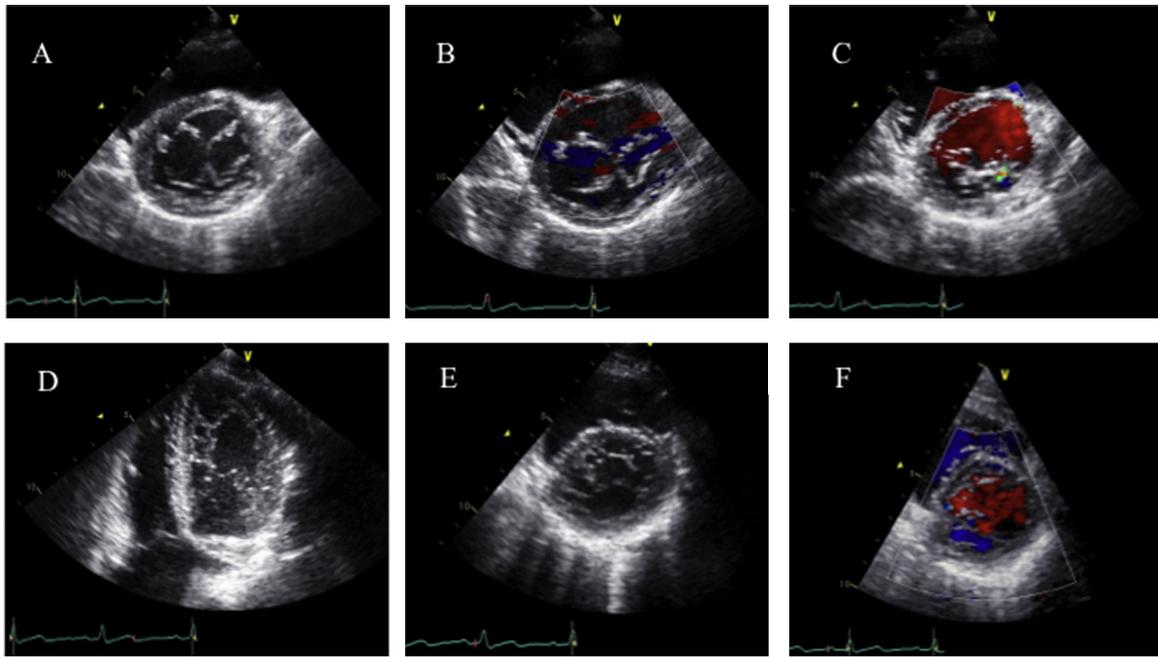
Short-axis view of the mitral valve showed two mitral orifices (A), the presence of two separate inflow jets (B), and only minor mitral regurgitation (C). Left ventricular trabeculations encircled the endocardium at the apical and midportions with blood flows into the myocardial gaps on color Doppler imaging (D–F).
